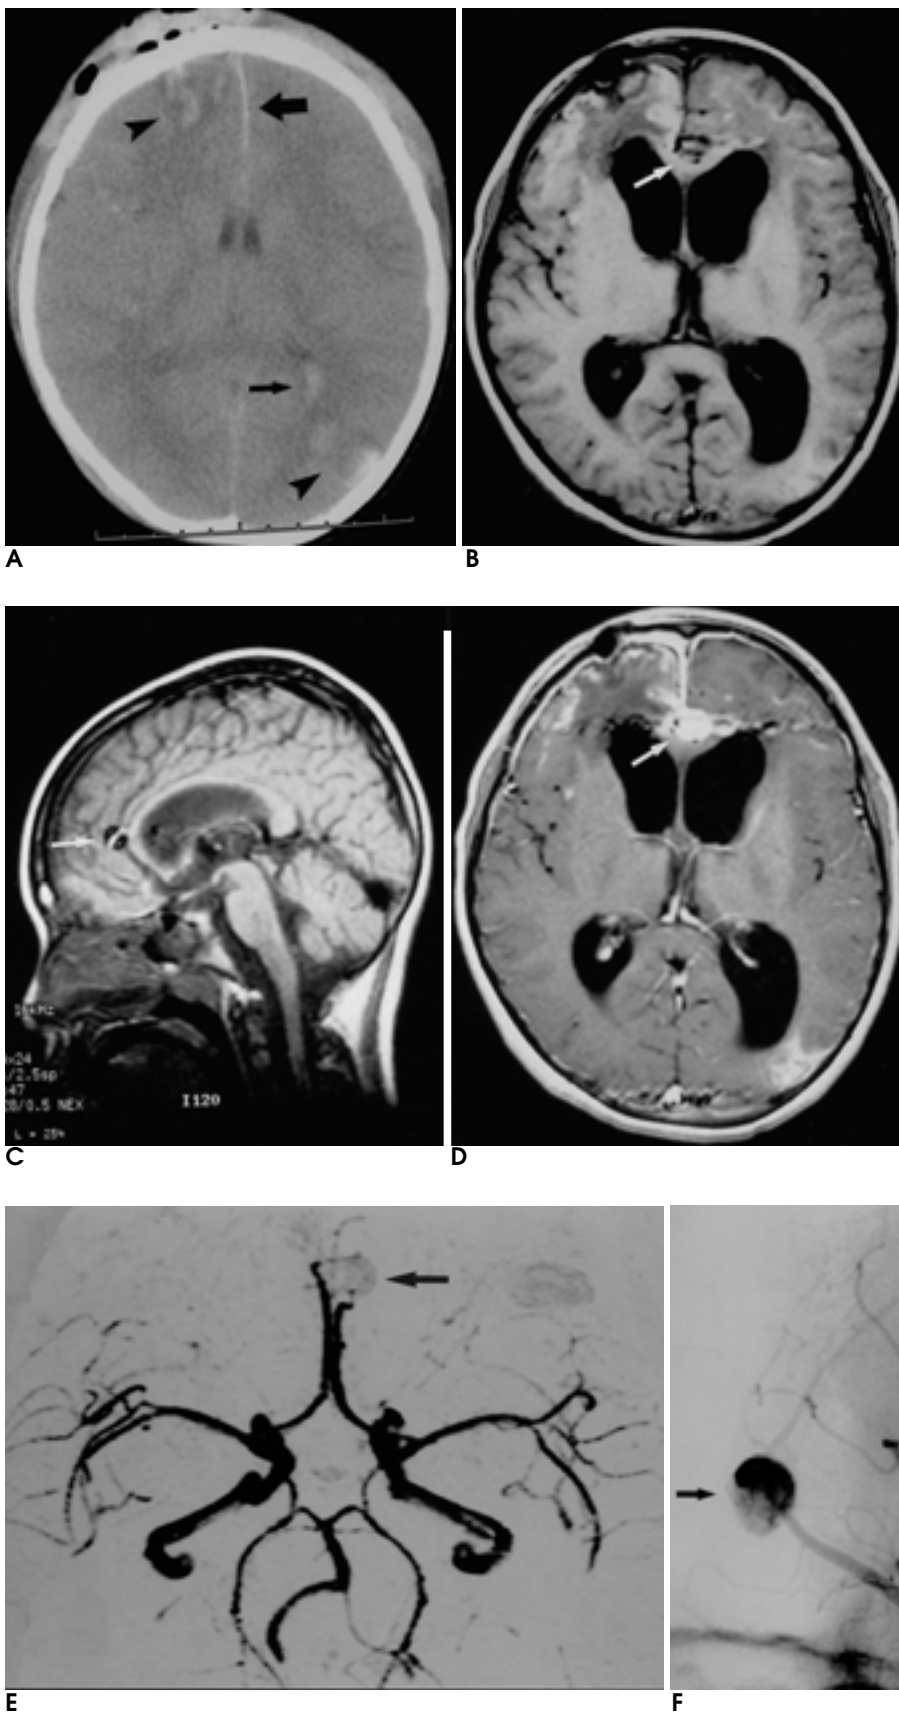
Patient 1. 8-year-old-child who experienced motor vehicle accident during bicycling. Initial precontrast CT (A) scan shows hemorrhagic contusions (arrow head) in the right frontal and the left parieto-occipital lobe, and subarachnoid hemorrhage (large arrow) in the anterior interhemispheric fissure and intraventricular hemorrhage (small arrow). Follow-up T1 weighted axial (B) and sagittal (C) MR scan shows nodular signal void (arrow) around the anterior falx. Strong nodular enhancement (arrow) around the anterior falx is showed on the enhanced T1 weighted scan (D). MR angiogram (E) shows aneurysm (arrow) in the anterior cerebral artery. Internal carotid angiogram (F) shows an aneurysm (arrow) in the anterior cerebral artery.
